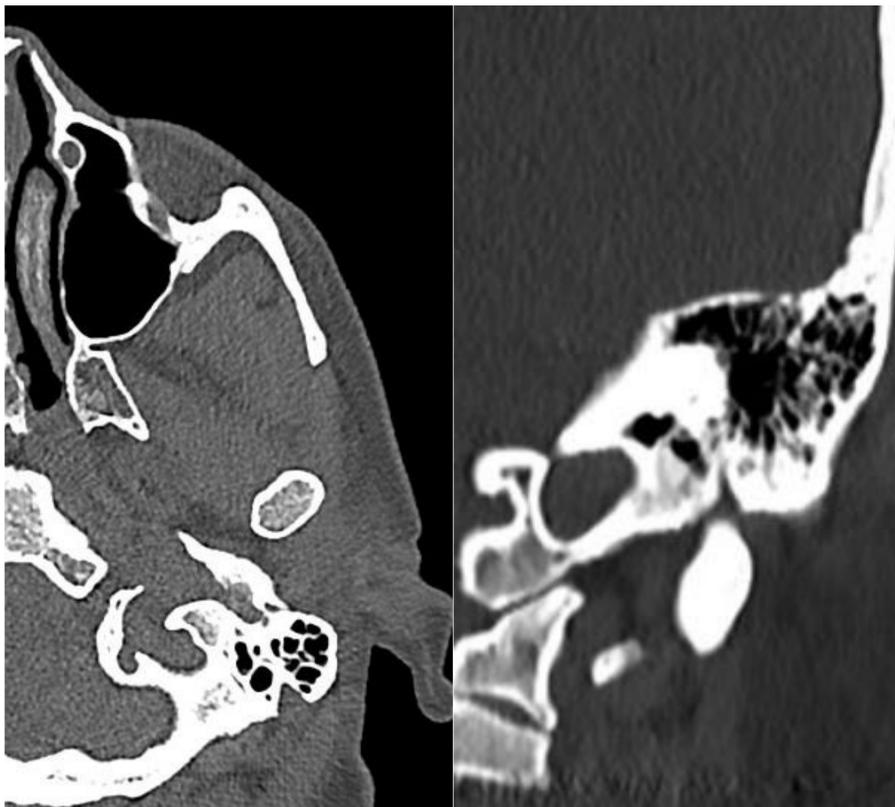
Axial CT scan showing enlarged left styloid at stylomastoid foramen
